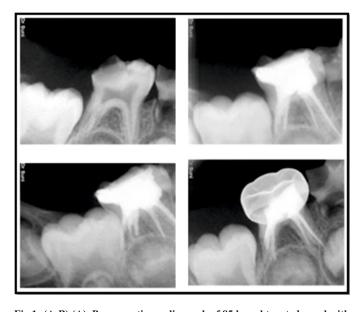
(A-B) (A). Pre operative radiograph of 85 b,c. obturated canal with metapex 85 from different angulations. (B) SSC with 85.
